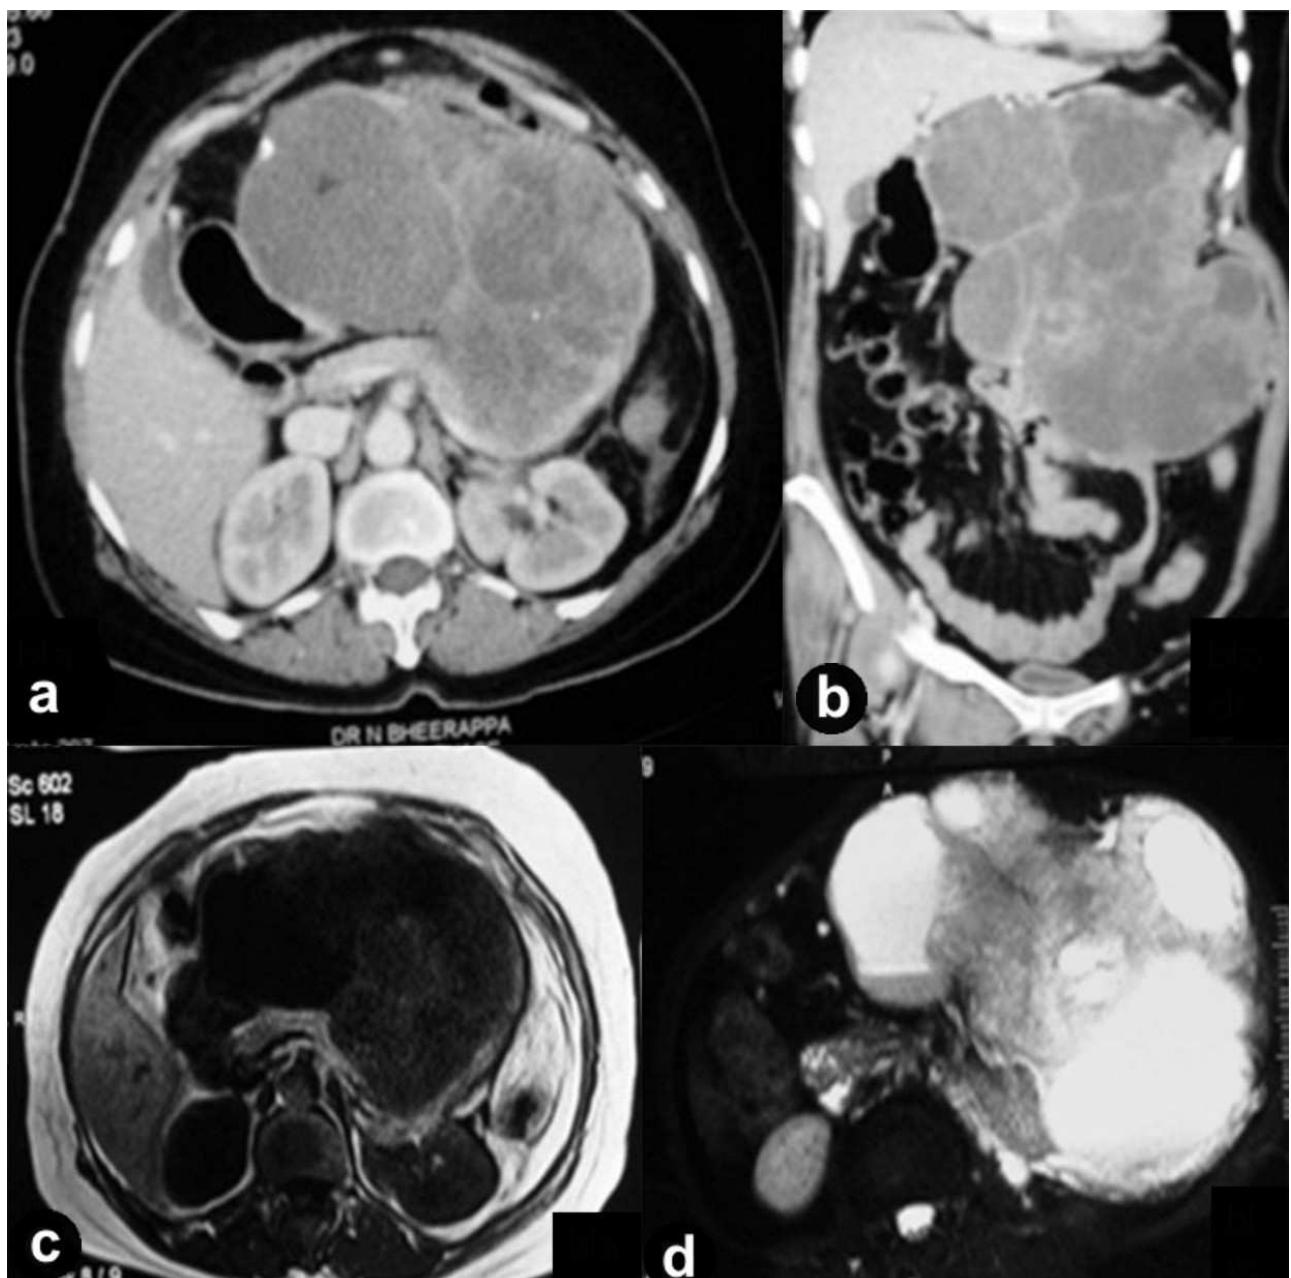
Contrast-enhanced computerized tomogram of the abdomen: axial (a.) and coronal (b.) sections showing a large lobulated heterogeneously enhancing mixed echogenic lesion in the region of the body and the tail of the pancreas. On magnetic resonance imaging, the mass was hypointense on T1-weighted imaging (c.) and hyperintense on T2- weighted imaging (d.).
